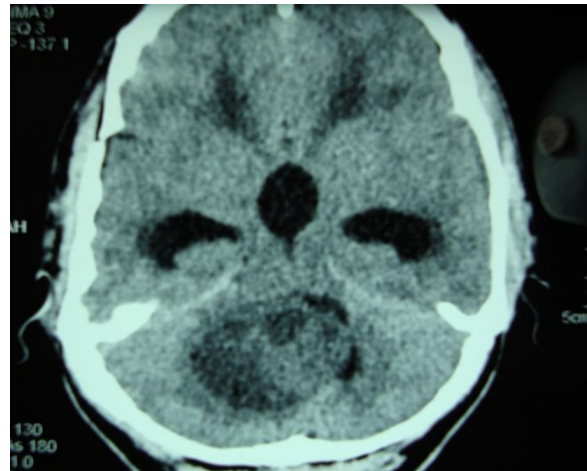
CT Head (plain) of one of our patient showing a mixed density vermian lesion with gross hydrocephalus.
